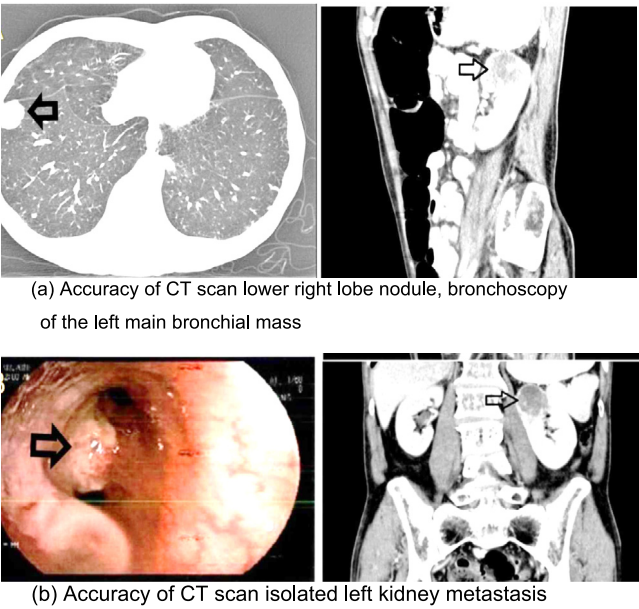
CT Scan image for kidney metastasis.
